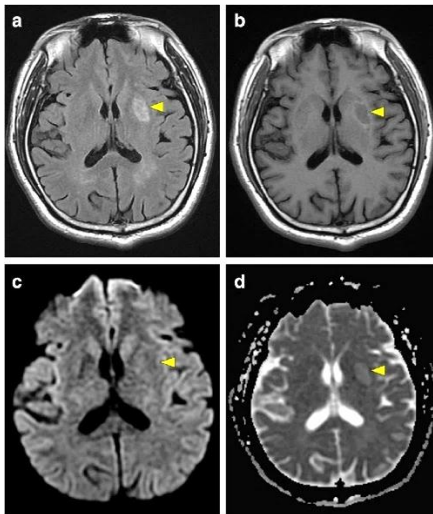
MR axial brain scans showing the presence of a subacute to chronic infarct in the left putamen, a: FLAIR image, b: T_1 weighted image, c: DWI image, d: ADC map. [18]
